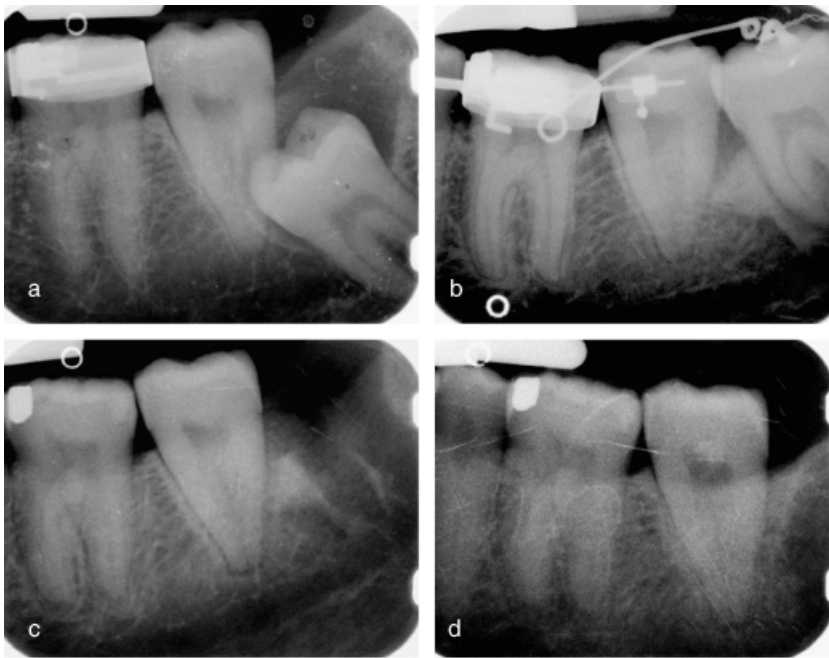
Periapical intraoral radiographs. (a) Before treatment, (b) at the end of the orthodontic treatment (before tooth extraction), (c) after third molar extraction and (d) 3-year follow-up.
